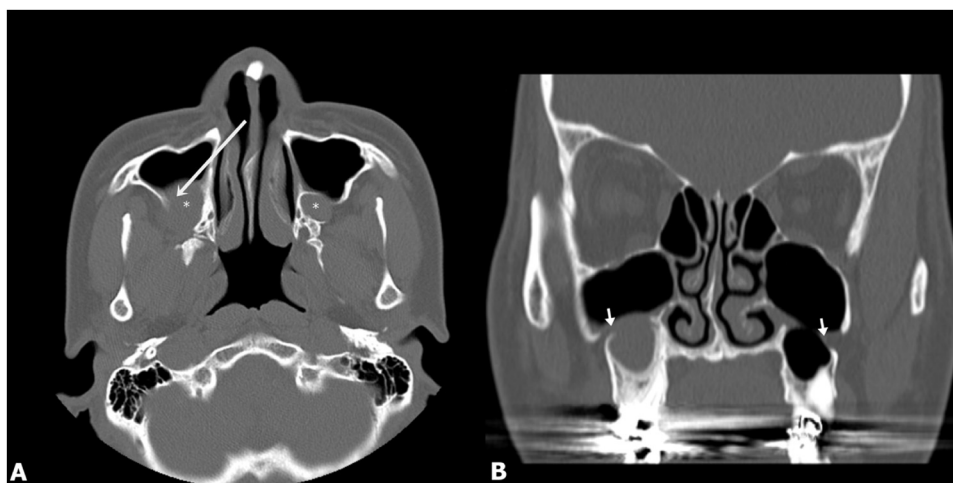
Axial computed tomography (CT) revealed bilateral postoperative maxillary cysts after orthognathic surgery on bilateral posterior aspects of the maxillae (1A, *). Coronal CT revealed the evidence of osteotomy (B, small arrow). The cyst was approached via inferior meatal antrostomy (long white arrow), and the antrostomy was made on the anterior portion of the lateral nasal wall. Note the thick bony portion on the posterior portion of the lateral nasal wall and the implant on the nasal dorsum.
